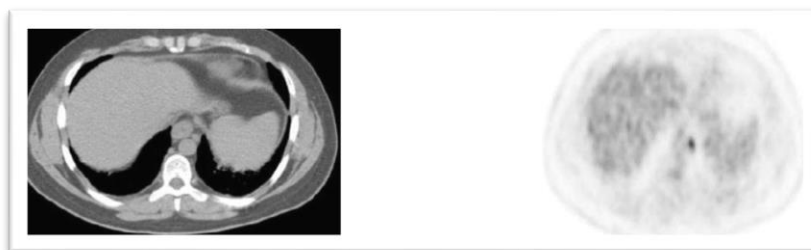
CT and PET scan image
